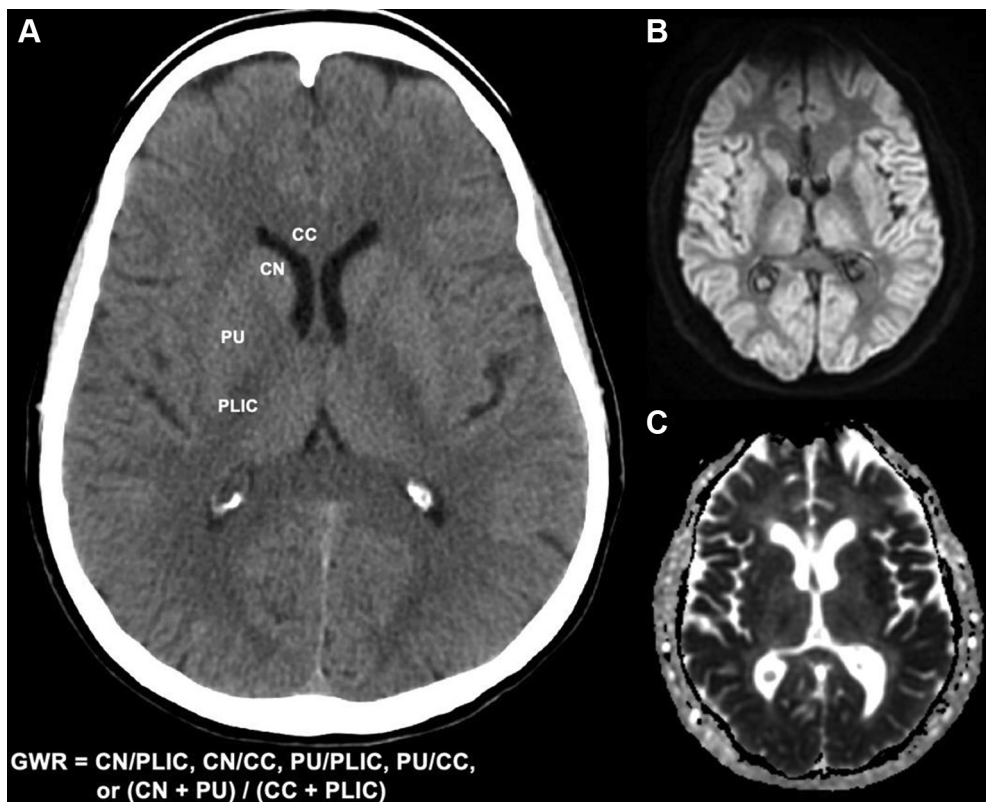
Example of a CT head (A) with corpus callosum (CC), caudate nucleus (CN), putamen (PU), and posterior limb of the internal capsule (PLIC) labeled. The gray-white ratio (GWR) can be calculated by measuring the Hounsfield units of the corresponding structures and calculating the ratio according to the equations provided. Example of magnetic resonance brain diffusion weighted imaging (DWI) (B) and corresponding apparent diffusion coefficient (ADC) (C) showing diffuse cortical and basal ganglia DWI diffusion hyperintensities and corresponding ADC hypointensities suggestive of a large burden of HIBI.
